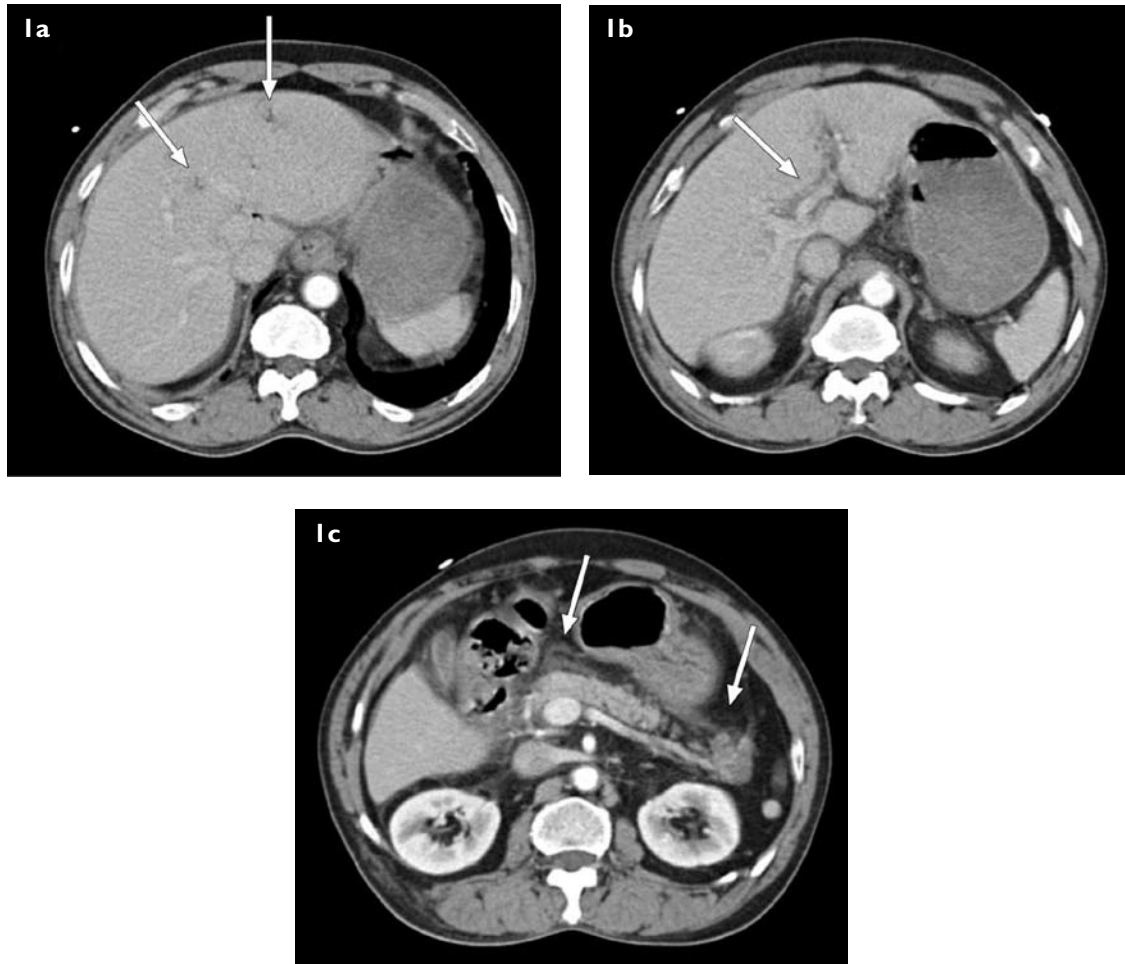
(a–c) Selected axial CT images obtained during the early portal venous phase.
